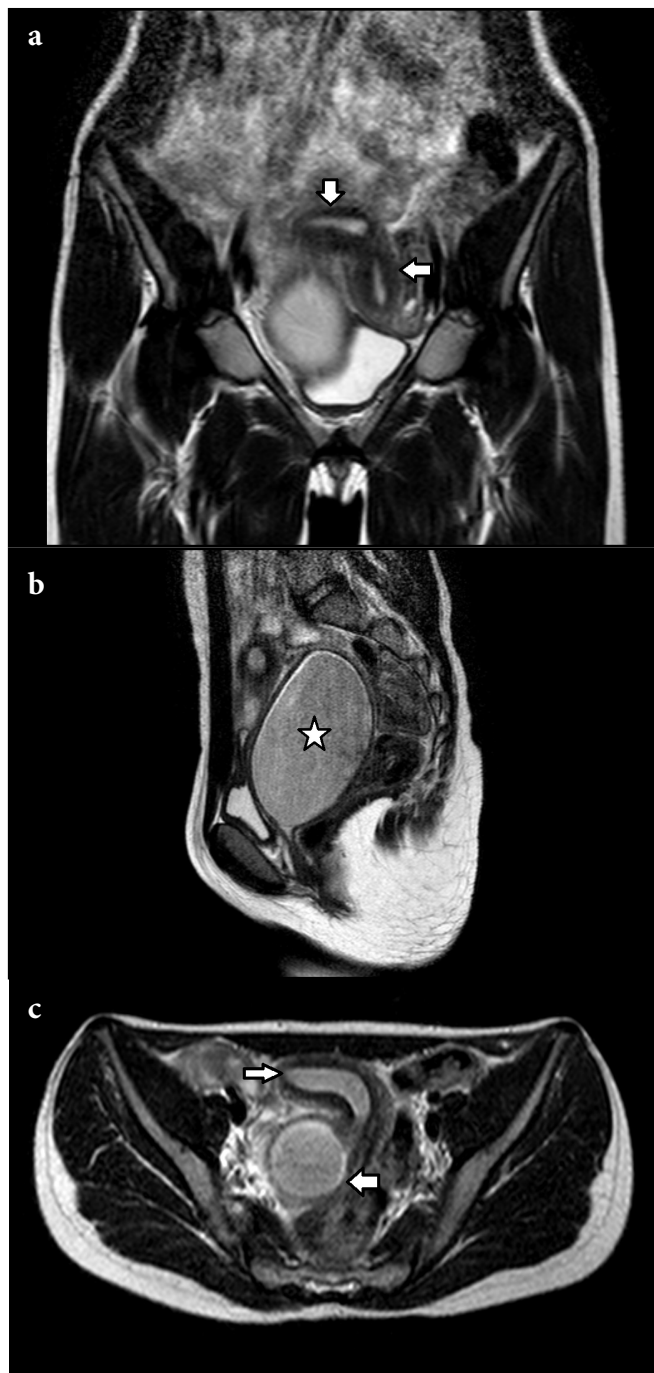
On MRI coronal T2-weighted image (a), an endometrial cavity showing two separate endometrial bands (uterine didelphys) surrounded by separate muscle layers was observed. And to the right of this, there is an obstructed blind hemivagina. Sagittal T2-weighted image (b) showing dilation of cervical canal with abrupt termination at vaginal fornix, resulting in obstructed hemivagina. Endometrial cavity was dilated and contained hemorrhagic collection. Axial T2-weighted image (c) showing two separate uterine horns and distention of endometrial cavity.
